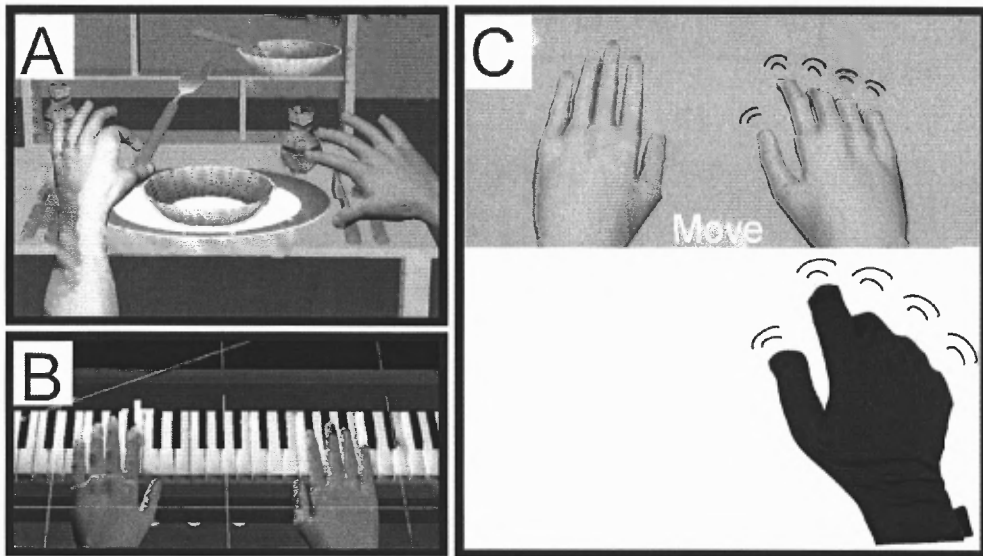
Training systems. A sample of our currently developed virtual environments. A. Dining Table Scene, B. Piano Trainer, C. Virtual Hands in the MRI, 5DT Glove.
